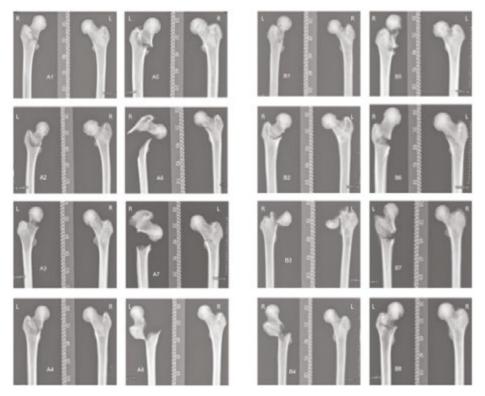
Plain anterior posterior radiographs after fracture. Some of the radiographs are mirrored so that the EF treated side is projected on the right hand side of the picture. The correct sides are displayed in the upper corners of each radiograph, and are marked by L and R. Femur pair B3 is the only pair with a complete failure of the EF treated femur.
